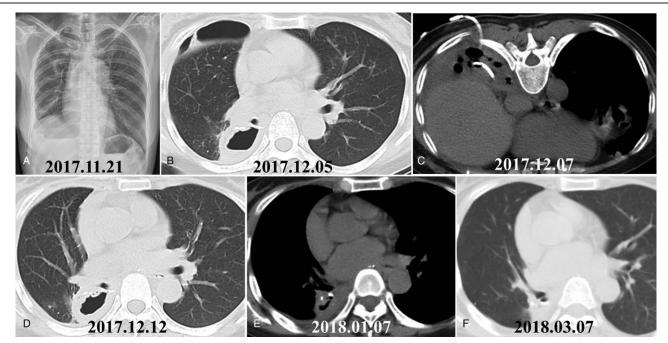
(A) Chest X-ray on the second admission showed generally normal thoracic cavity. (B) CT on 37th POD indicated right-sided pneumothorax and thinkwalled empyema cavity. (C) A 14 French catheter was reinserted. (D) Pneumothorax was disappeared after chest drainage. (E) The empyema cavity was shrunken 1 month after therapy. (F) On the 3-month follow-up, CT image showed closure of the BPF.
